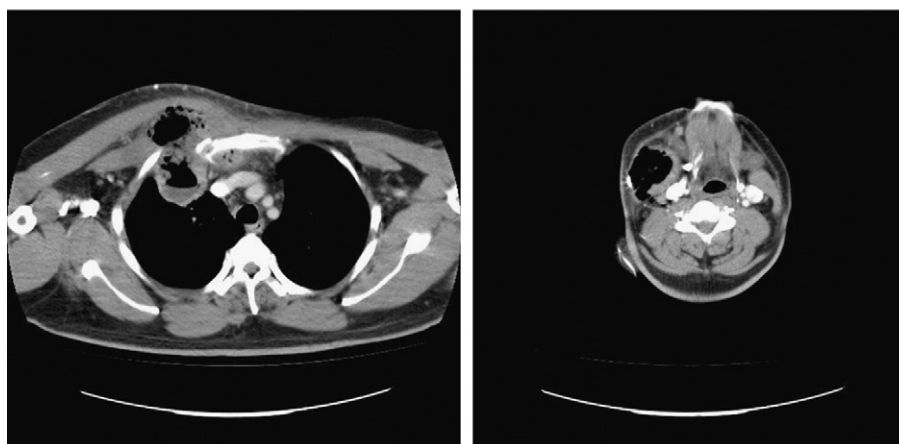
CT scan of the chest and neck showed a 5 cm right-sided parapharyngeal abscess communicating with the anterior mediastinum and with an $8 \times 2.5 \times 12$ cm abscess underlying the pectoralis major and minor. The chest wall abscess had eroded through the first right costal cartilage, into a 5 cm apical lung abscess.
